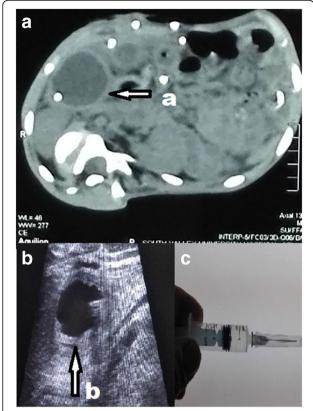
a CT abdomen axial view of a 13-year-old male patient showing right hypochondrial cyst (a arrow). b Abdominal ultrasonography done for the same patient, and right hypochondrial cyst was found (b arrow). c Ultrasonic-guided aspiration was done from this cyst, and the aspirate was clear CSF
